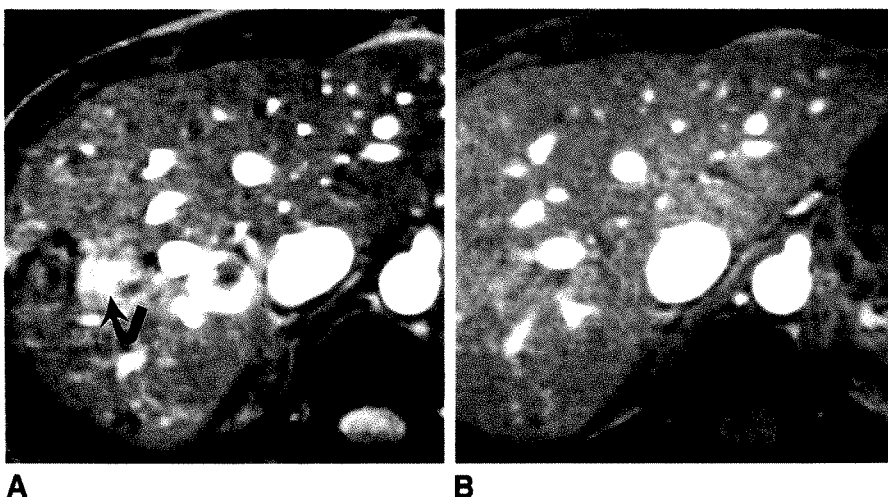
A, Fast imaging with steady-state precession (FISP), 80°-flip-angle MR image. Phase-related artifact (arrow) is accentuated at largest flip angle.
